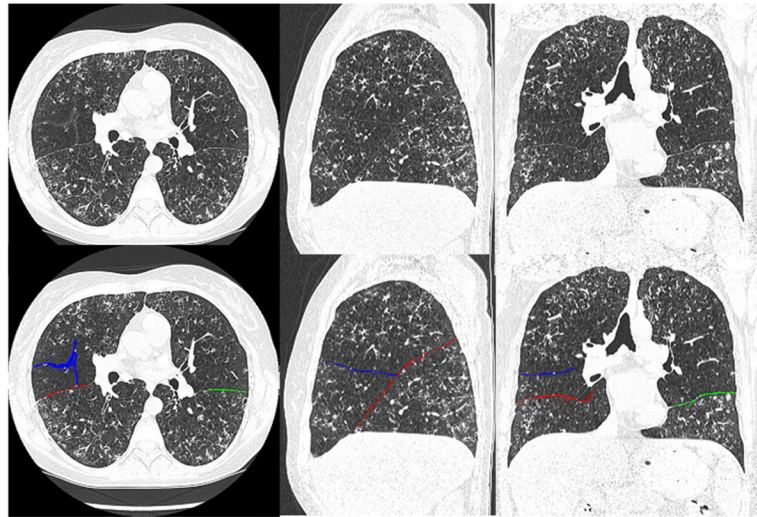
An example showing the detected pulmonary fissures by the proposed scheme in an abnormal examination with severe bronchiectasis (cystic fibrosis). The top row shows the original CT images, and the bottom row shows the identified fissures in overlay. The left, middle, and right columns show the axial, the sagittal, and the coronal views, respectively.
